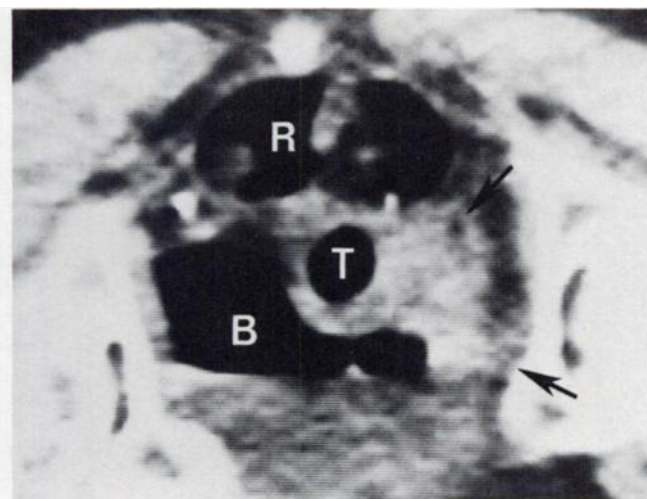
Case 2. CT scan with patient prone after instillation of 150 ml carbon dioxide into bladder (*B*) via catheter and insertion of vaginal tampon (*T*). Bladder neoplasm (*arrows*) extends alongside vagina posteriorly toward rectum (*R*) and laterally toward pelvic wall (*lower arrow*), correlating with results of bimanual examination. Rectum contains gas and feces.
